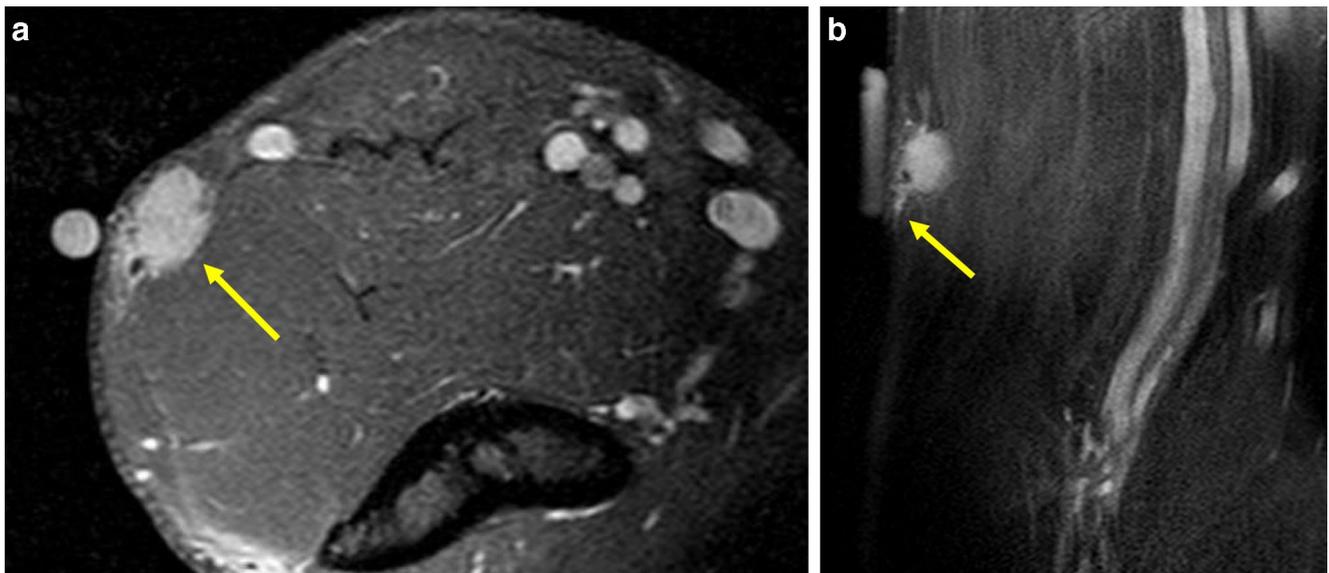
A 55-year-old man with a palpable elbow mass. a Axial post-contrast fat-suppressed T1-weighted MR image shows an enhancing 2-cm subcutaneous mass (*arrow*), involving the investing muscle fascia. b Coronal proton density-weighted MRI shows a subtle tumor tail (*arrow*)
